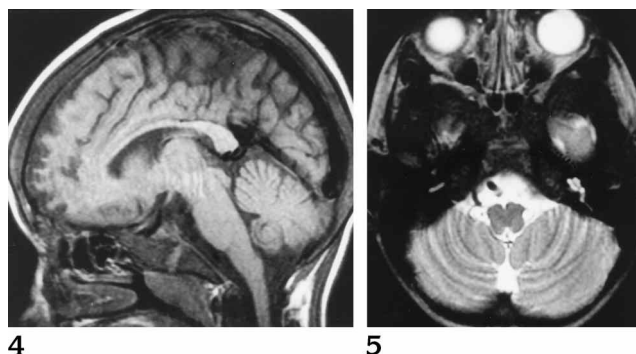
Sagittal T1-weighted MR image of a 7-year-old child shows diffuse low signal in the clivus and calvarium.
